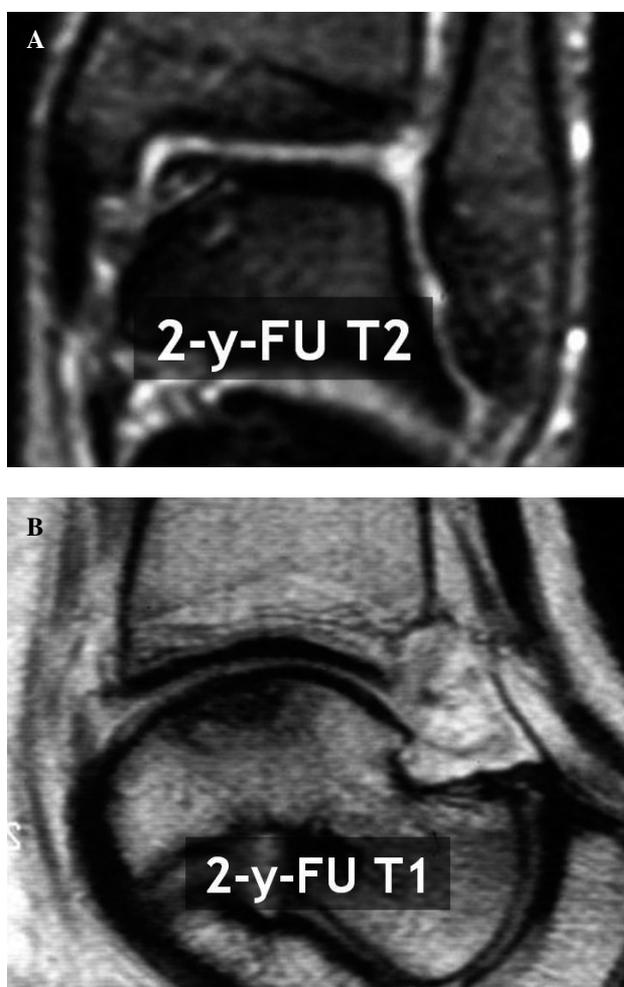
MRI followup: coronal reformation (A) and parasagittal reformation (B).
